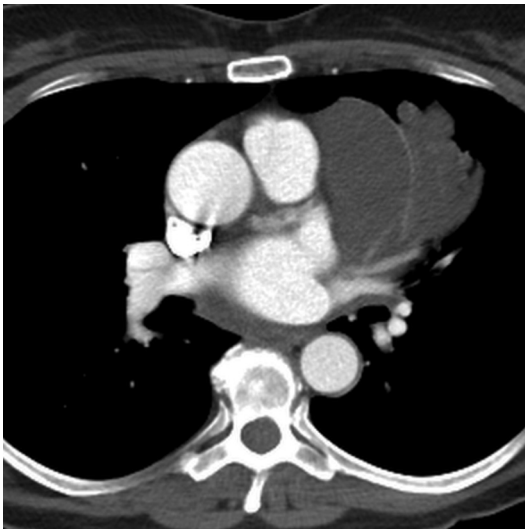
Lymphangioma. Contrast-enhanced axial CT shows a left prevascular mediastinal multilocular cystic lesion with intrinsic septation. The lesion encases the left tracheobronchial tree and extends into the adjacent left upper lobe.
